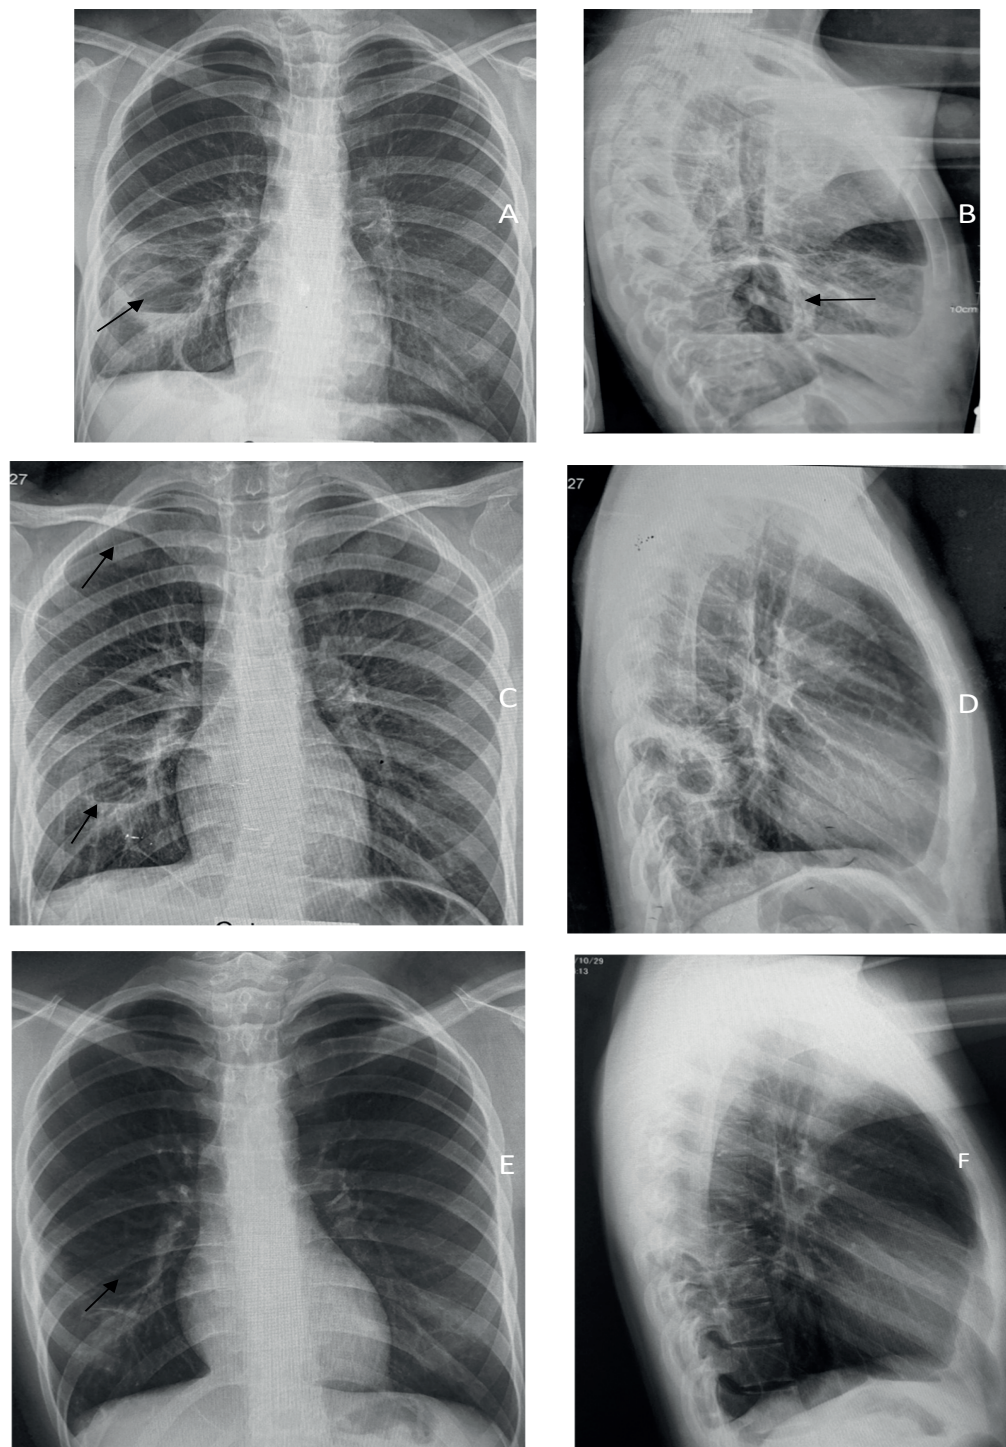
Patient C., 15 years old. Chest X-ray in 2 incidences (right profile) taken 1.2 months (A, B), 3.4 months (C, D), and 12 months (E, F) from the time of surgery. The presence of a small cavity with drained hydro-aerial content, located in the lower lobe of the right lung, is determined, which gradually decreases in size until it disappears completely
